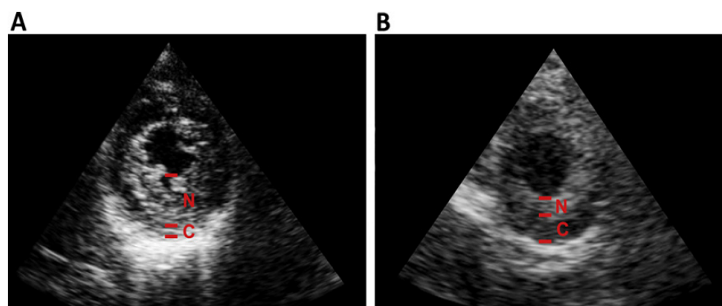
Representative example of echocardiographic measurements in the parasternal short-axis view in a patient with LVNC (A) compared with one with AVS (B). C, compacted myocardial layer; N, noncompacted myocardial layer.
